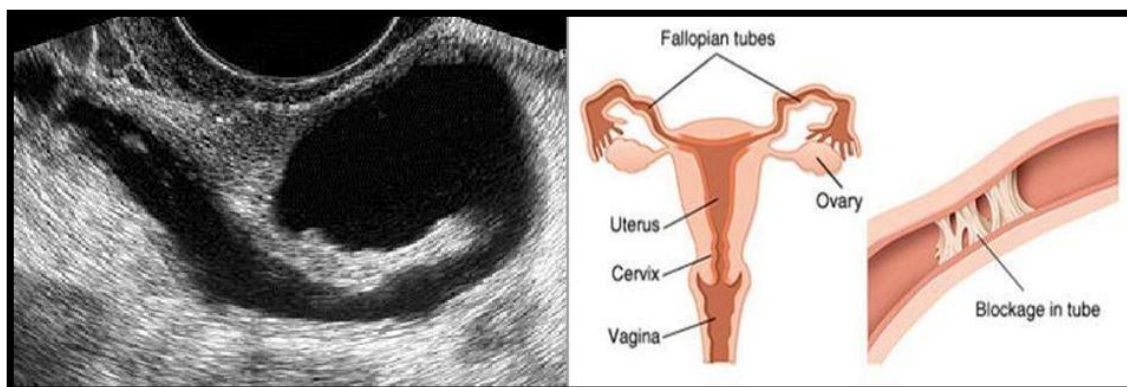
Depiction of Ultrasound Image of Polycystic ovary and tubular blockage.
